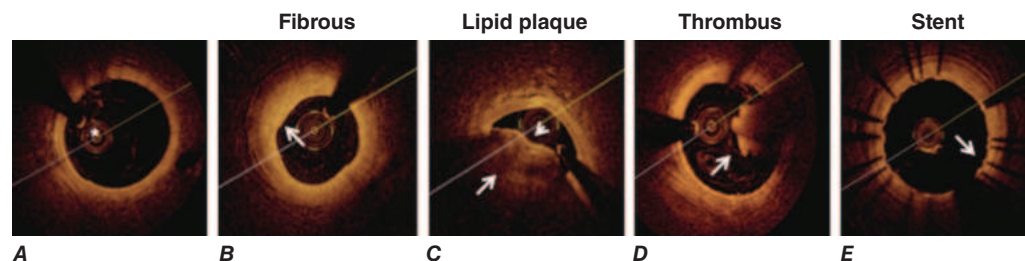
Optical coherence tomography imaging. A. The optical coherence tomography (OCT) catheter (*) in the lumen of a coronary artery with limited neointima formation. The intima is seen with high definition, but unlike intravascular ultrasound imaging, the vessel media and adventitia are not well visualized. B. A fibrous plaque (arrow) is characterized by a bright signal. C. A large, eccentric, lipid-rich plaque obscures part of the vessel lumen. Because lipid in the plaque absorbs light, the lipid-rich plaque appears as a dark area with irregular borders (arrow). The plaque is covered by a thin fibrous cap (arrowhead) typical of a vulnerable plaque. D. A thrombus (arrow) adherent to a ruptured plaque that is protruding into the vessel lumen. E. A coronary stent is that is well apposed to the vessel wall. The stent struts appear as short bright lines with dropout behind the struts (arrow).
